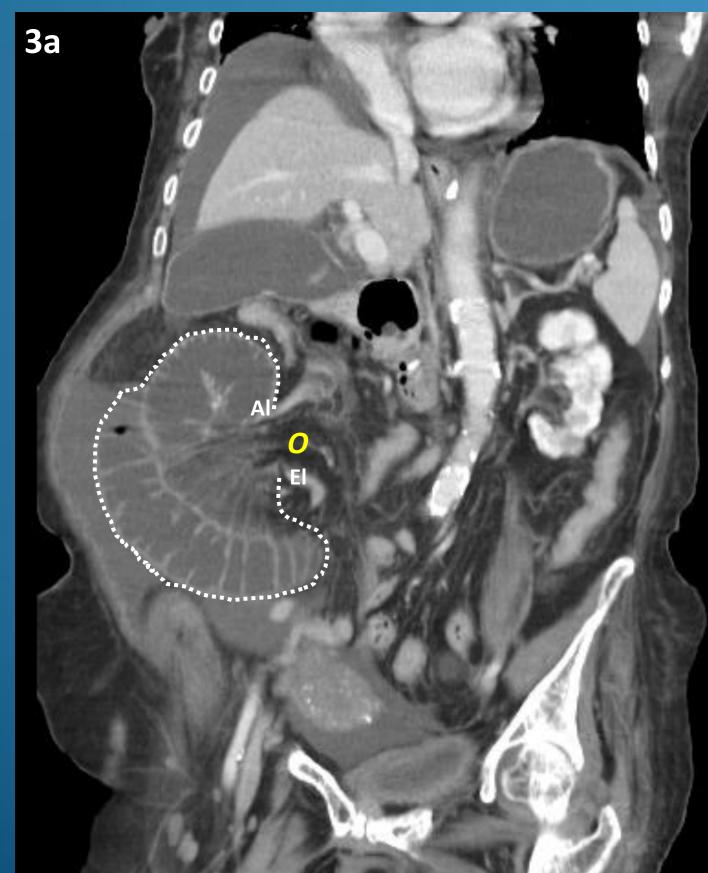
A 90-year-old woman, with a operation history of repair of ventral hernia due to bowel incarceration, presented with abdominal pain for 2 days. Abdominal CT in coronal (3a) and axial (3b) sections demonstrate a cluster of dilated small bowel loops (within dotted line, 3a) with poor contrast enhancement of bowel wall (white arrow) and its mesentery showing edematous change (white arrowhead). The operation demonstrates strangulated IH secondary to an adhesive band. The narrowed afferent (AI) and efferent (EI) loops were passing through the hernial orifice (), forming by an adhesive band.
